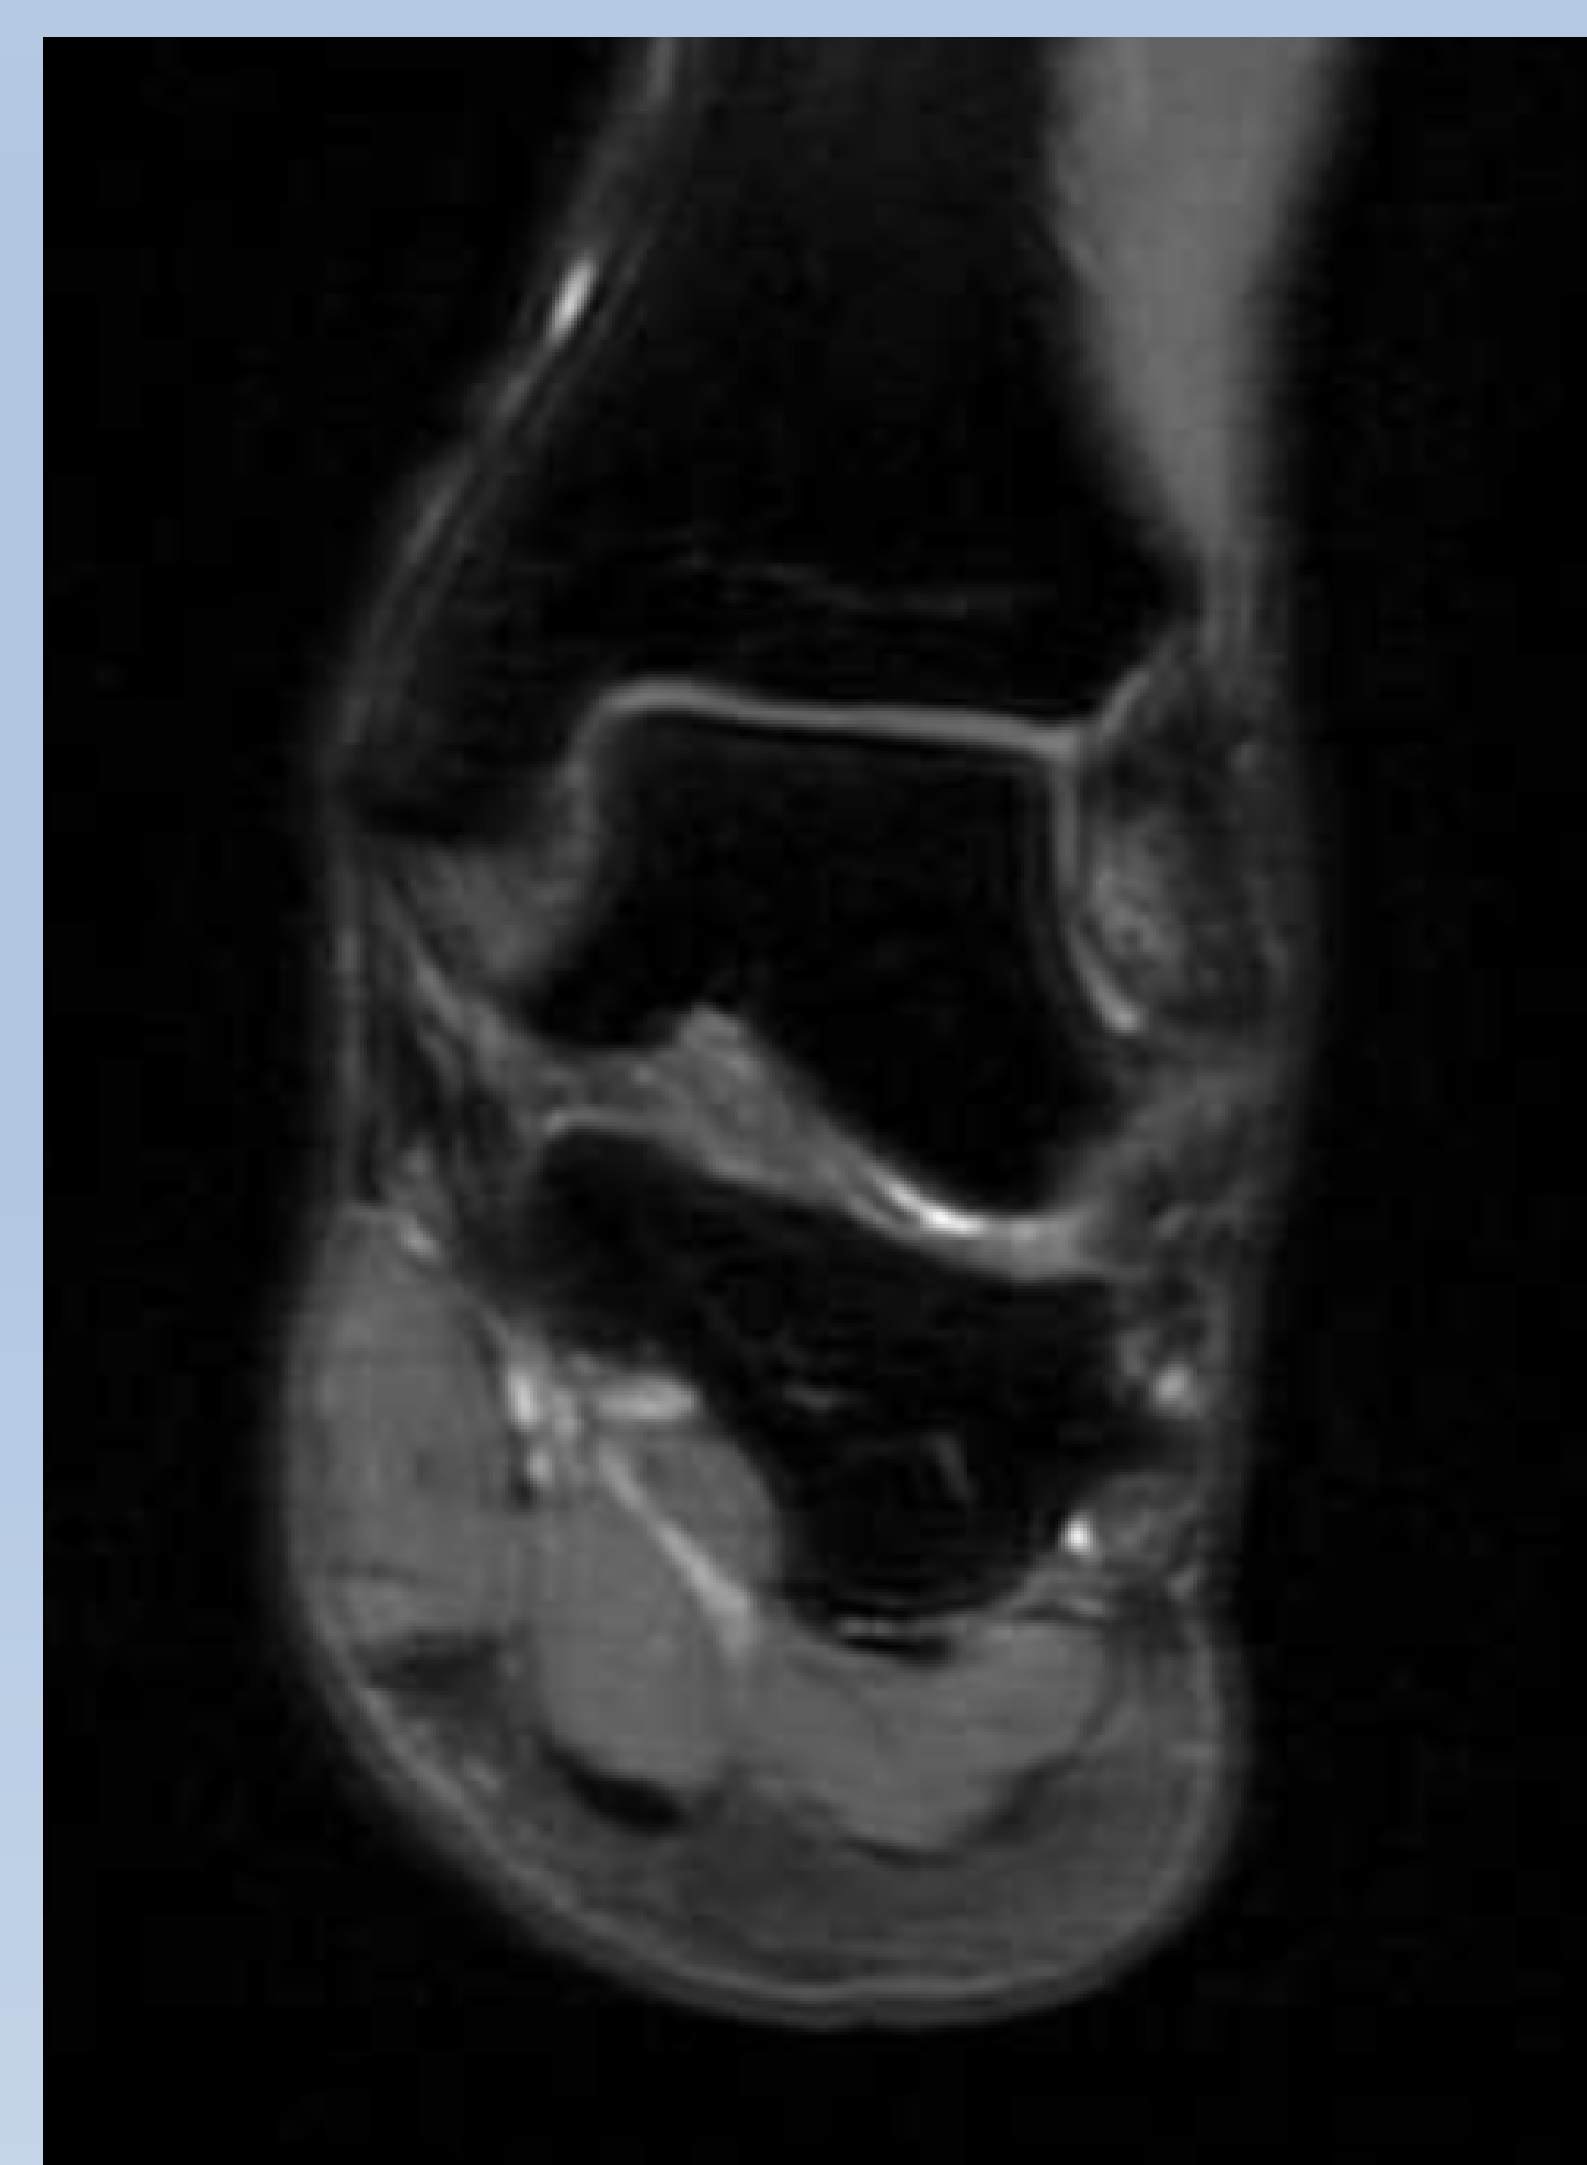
Coronal T2 MRI Left Ankle
